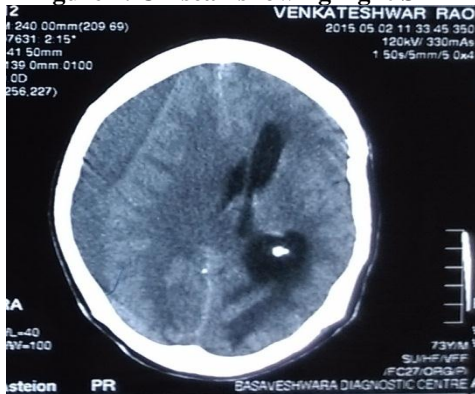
CT scan showing Left SDH
